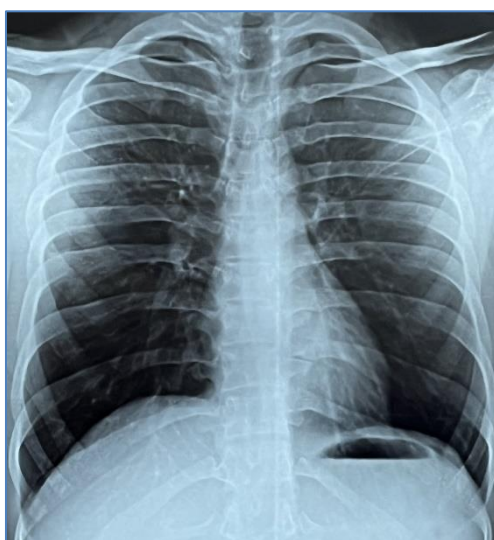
Chest x-ray showing complete resolution of coin lesion or round pneumonia
